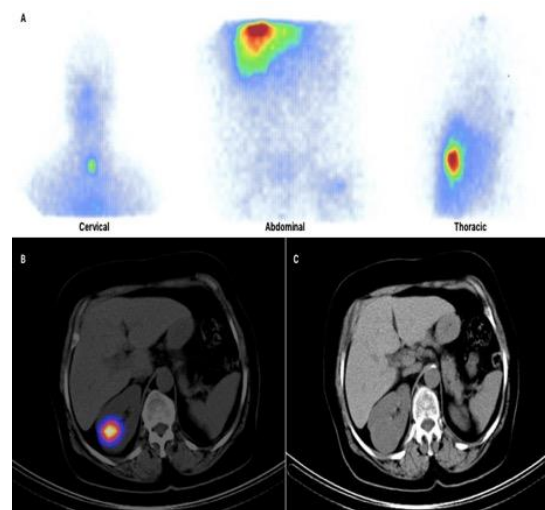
Remnant thyroid tissue in the thyroid bed, metastatic involvement of both lungs and the proximal portion of the left femur were depicted on planar scintigraphy (A). Also, an ill-defined lesion with intense radiotracer uptake was noted in the cortex of the right kidney on SPECT/CT (B) and CT images (C). This intense activity in the cortex of the right kidney corresponds to a cystic lesion of the right kidney with physiologic uptake.
